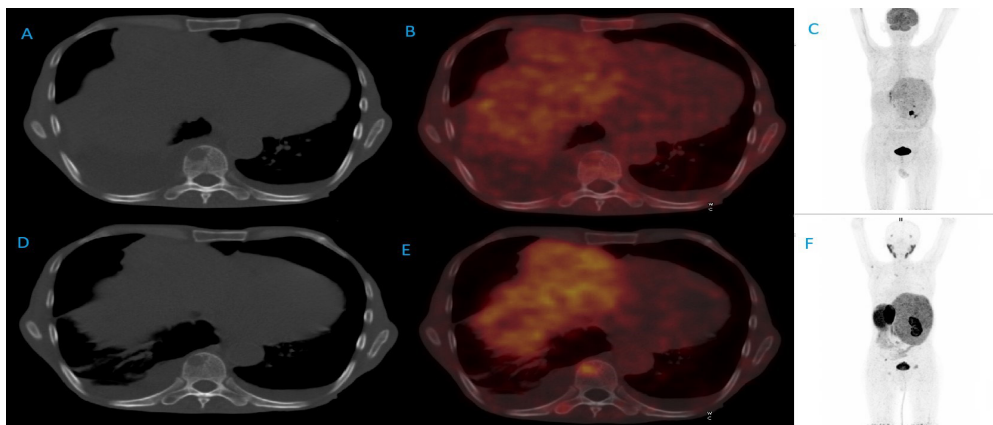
BFigure 1. Axial tomography image (A), axial positron emission tomography/computed tomography image (B), MIP image (C) in FDG PET/CT study and axial tomography image (D), axial positron emission tomography/computed tomography image (E), MIP image (F) in Ga-68 PSMA PET/CT study of lesions observed in T9 vertebral corpus and right transverse process of a patient with HCC.
